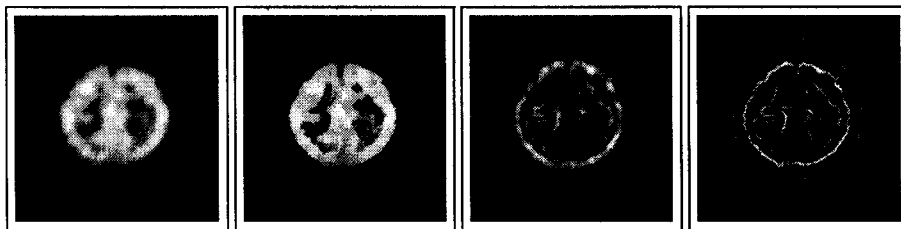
Example of deblurring applied to a SPECT image. From left to right: the original 128×128 SPECT image, the image after a single step of deblurring with a 3×3 square, the inner gradient of the original, and the inner gradient of the deblurred version.
